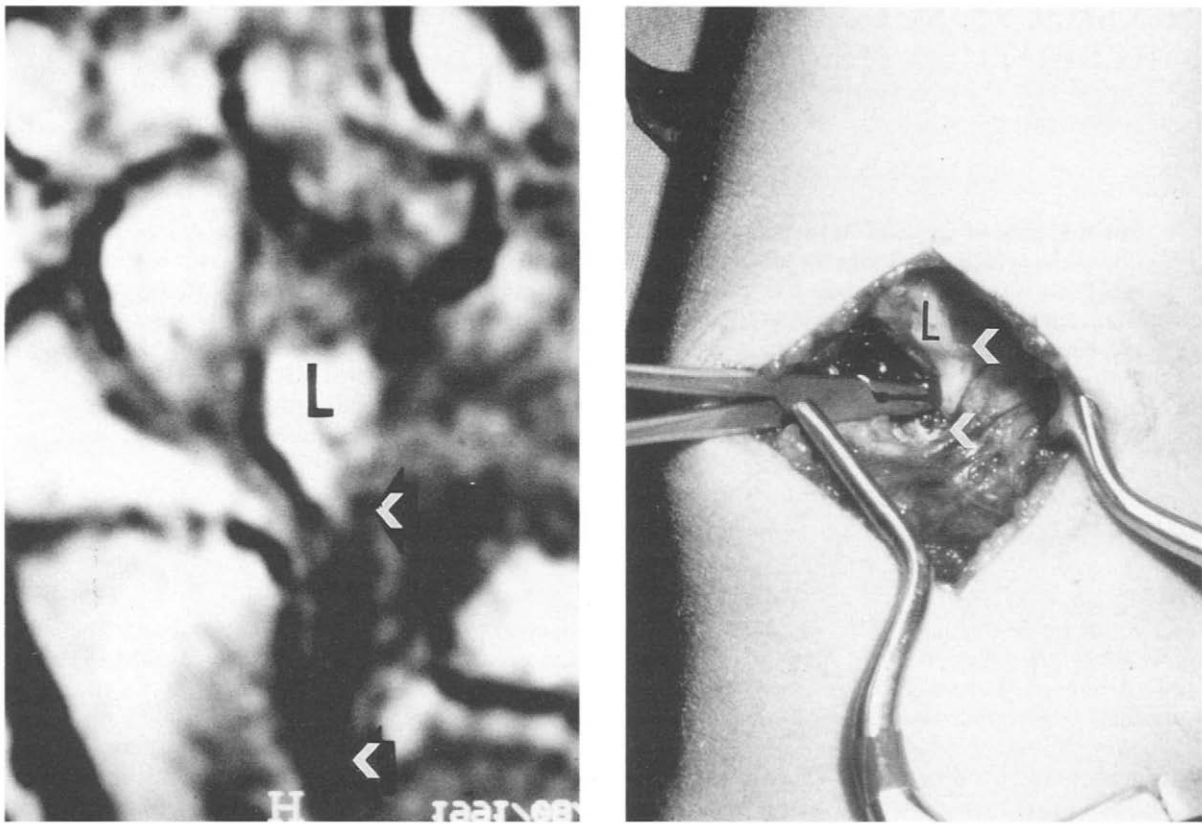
MRI and operative images of the abnormal volar radio-lunate ligament in a reverse Madelung deformity.
